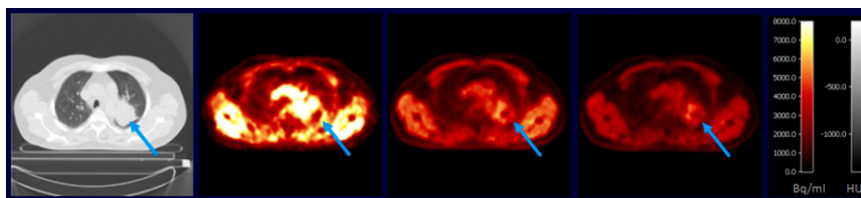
^{18}F -HX4 quantification of hypoxia in non-small cell lung cancer. Left to right: low-dose CT; ^{18}F -HX4 PET acquired 25–30 minutes after injection; ^{18}F -HX4 PET acquired 240–270 minutes after injection.
